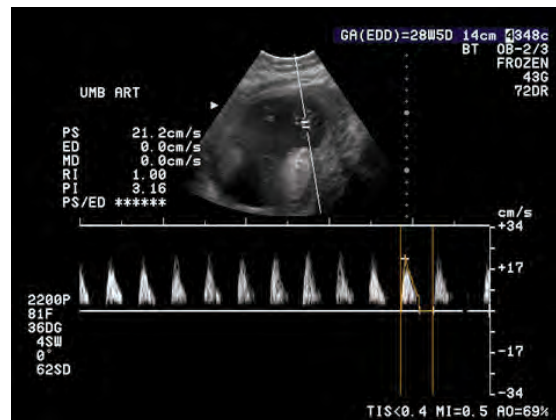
Umbilical Artery Doppler Waveform Patterns
